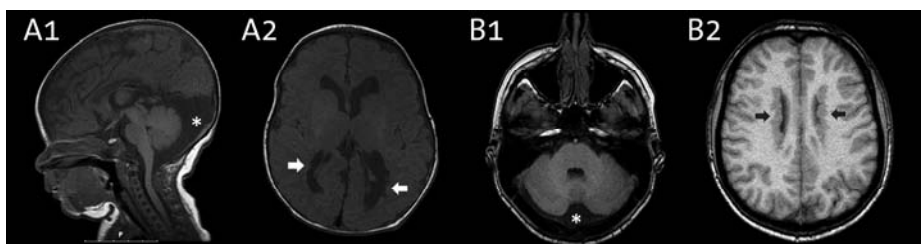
neuroimaging characteristics of a child (patient 2) in A1 and A2, and an adult (patient 5) in B1 and B2. All are T1 weighted MRI images. Note the periventricular nodular heterotopia (denoted by arrows) and the enlarged retrocerebellar space (denoted by a star).
